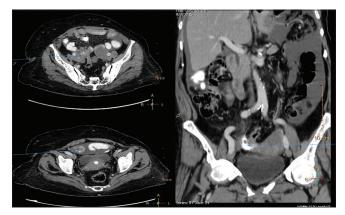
The axial and coronal contrast-enhanced computed tomography images showing the calcified soft tissue peritoneal metastasis
